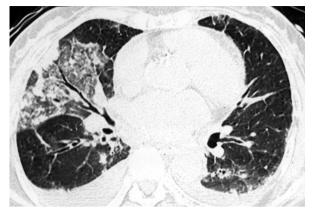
Chest CT showed ground glass opacities in the right lower lung and some on the left side.
